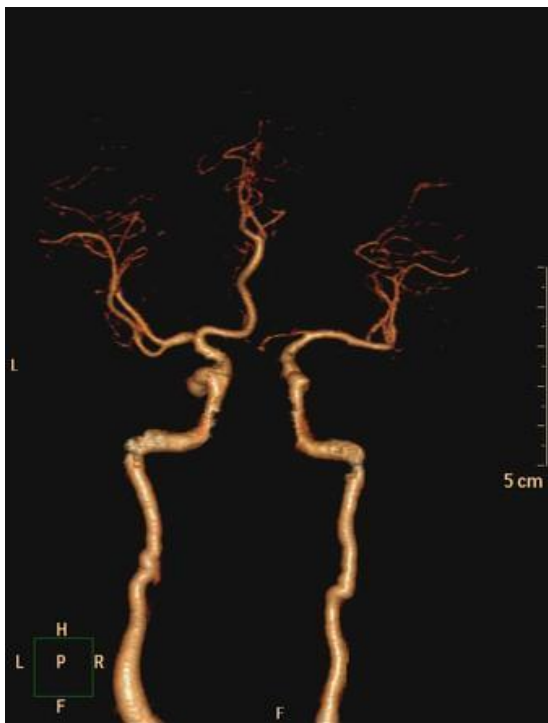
3D CT angiogram depicting an azygous ACA with hypoplastic A1 segment of the left ACA (Image courtesy of radiopedia.org)
